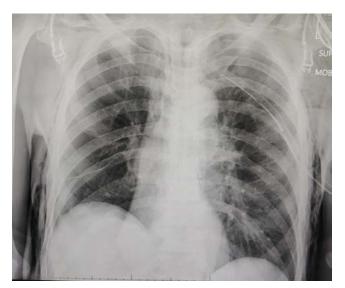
Mobile chest X-ray – after intercostal drain insertion
